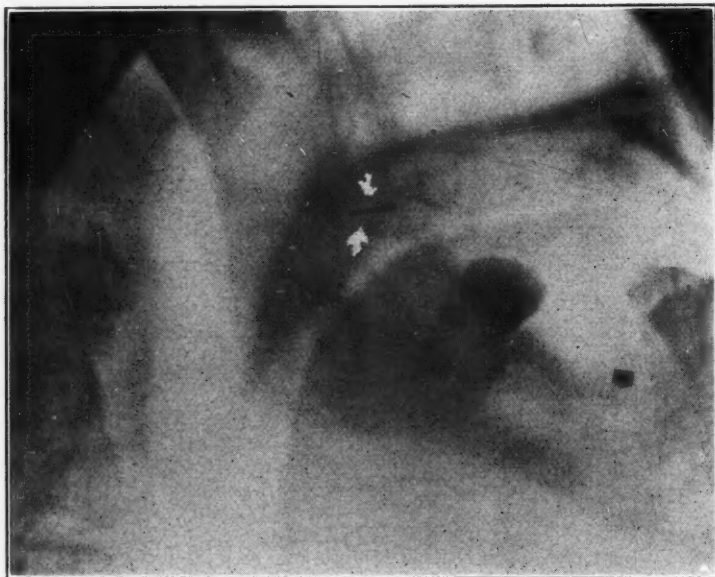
G. W., male, aged sixty-two years. Broken needle in jaw. The referring dentist said novocaine was being injected when patient jerked suddenly, resulting in the needle breaking. A piece about one-half inch in length was retained according to our x-ray findings. Under ether anesthesia an incision was made over the area of injection, and the tissue was gently retracted. After a search of about one hour needle was removed. These cases are indeed tedious ones, but in my opinion the needle should be removed as soon as possible after the accident.
